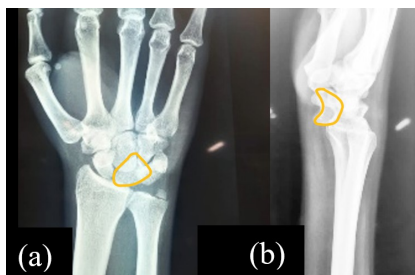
Pre-operative radiographs; (a) Piece of pie sign in PA view; (b) spilled tea cup sign in lateral view
